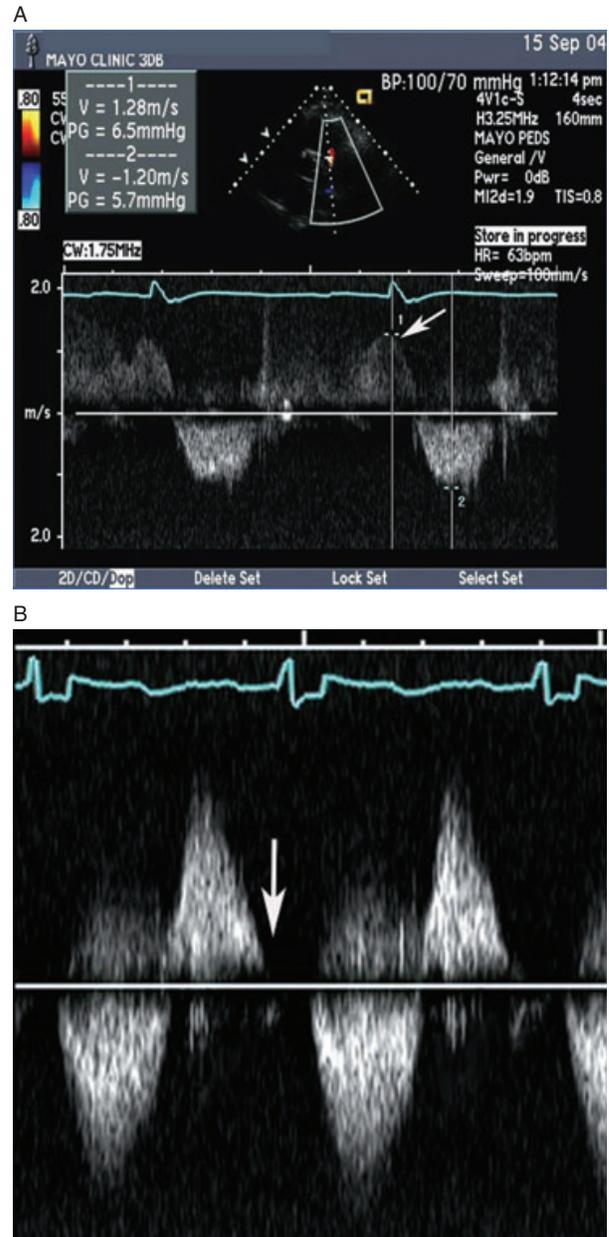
Continuous wave Doppler signal at the level of the pulmonary valve in a patient with mild pulmonary valve regurgitation demonstrates normal systolic forward flow and reversed flow that continues throughout diastole indicating mild pulmonary valve regurgitation. The low end diastolic velocity (A) suggests normal pulmonary artery diastolic pressure. In patients with (B) severe pulmonary regurgitation the regurgitant diastolic velocity (arrow) peaks early and decreases rapidly as the pulmonary artery to right ventricular pressures rapidly equilibrate, leading to early termination of the continuous wave Doppler signal.
